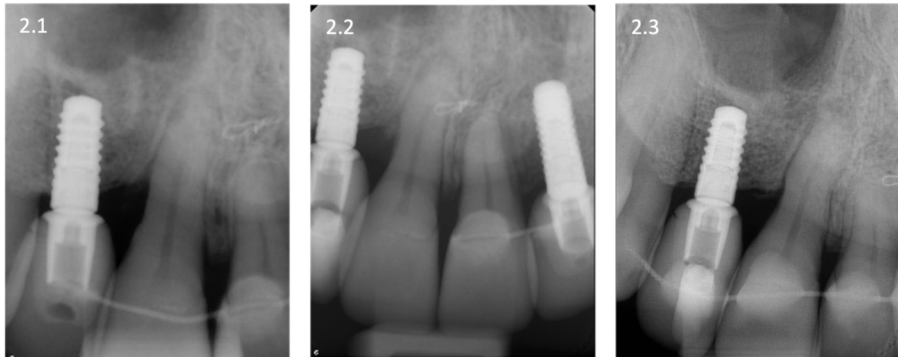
X-rays (2.1: Baseline X-ray; 2.2: X-ray after surgery; 2.3: X-ray 36 months after surgery)
